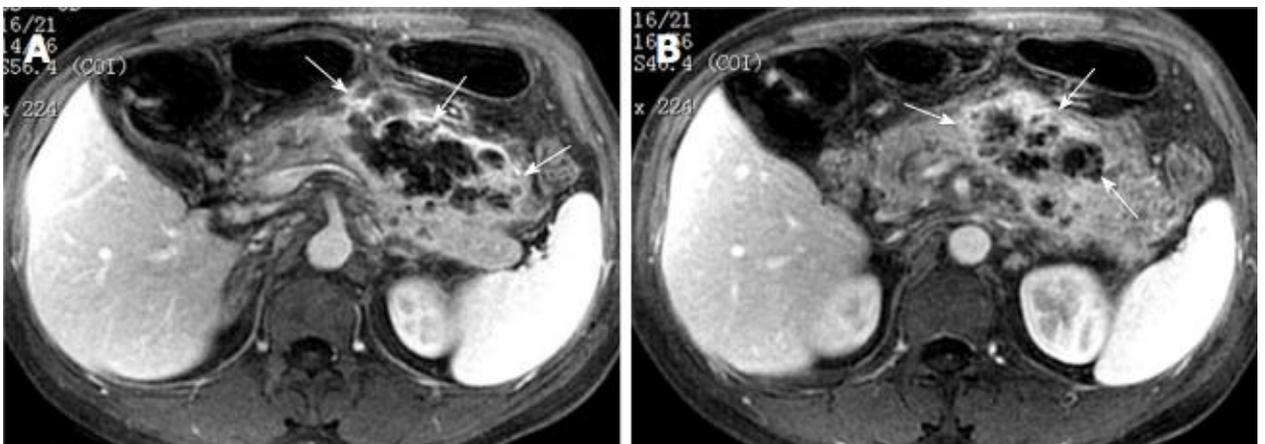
A 39-year-old patient with acute pancreatitis and peripancreatic cellulitis. Contrast-enhanced T1-weighted images demonstrate multilocular structure with ringed hyperintensity inclusions and NOT, contents (for "wasp nest" type) — white arrow in A and B pictures.
